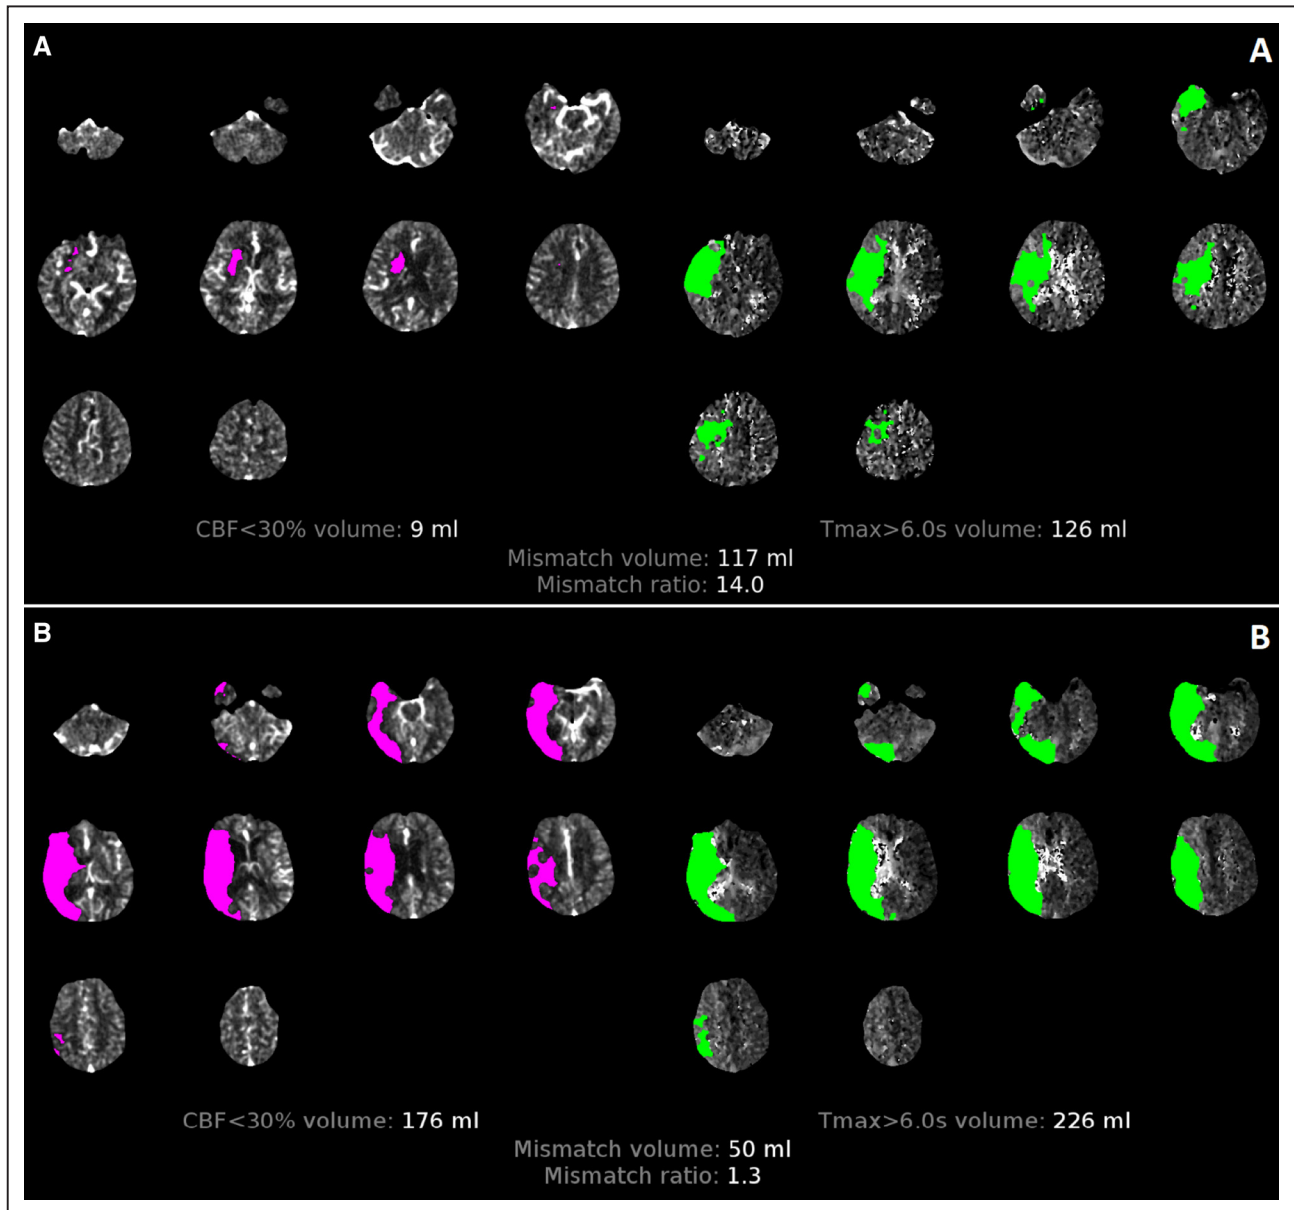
Computed tomography (CT) perfusion imaging processed by RAPID software showing the ischemic core and perfusion deficit. Above, a patient with an occlusion of the M1 segment of the right middle cerebral artery who has a target mismatch profile is shown (A), that is, small ischemic core (pink), considerable tissue at risk for infarction (green) and a large mismatch ratio. Below, perfusion imaging of a patient with a right-sided M1 occlusion and a malignant perfusion profile is shown (B). This patient has a large ischemic core (pink) which largely overlaps the perfusion deficit (green). CBF indicates cerebral blood flow.
